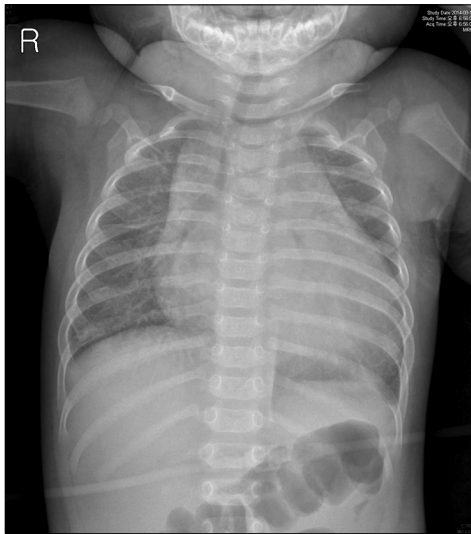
Chest X-ray showed cardiomegaly.
